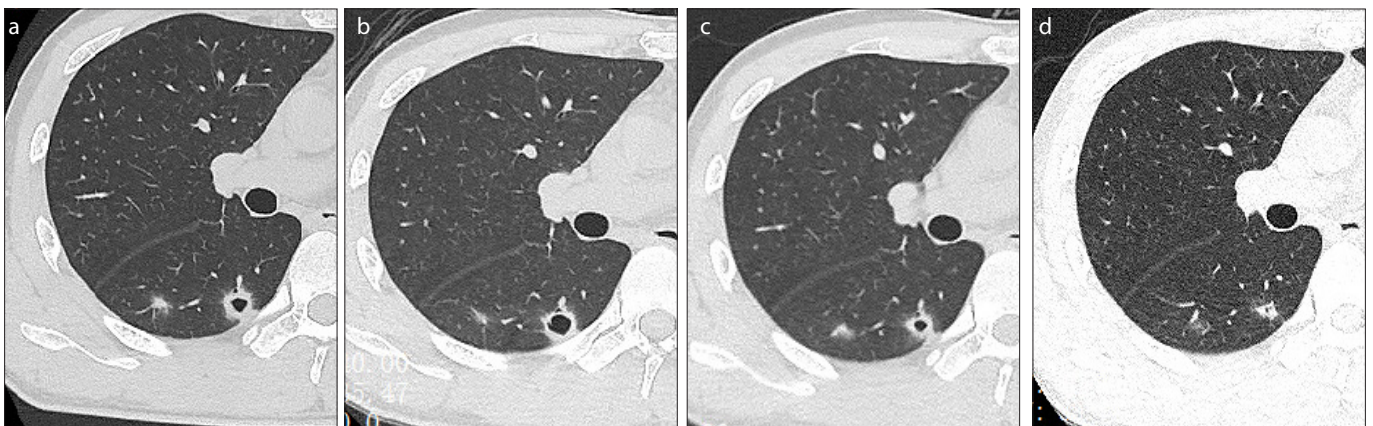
a–d. Imaging changes in a 27-year-old patient with COVID-19 during the course of treatment. Axial lung CT image (a) taken on January 24, 2020 showed some small nodules and a cavitation in the dorsal segment of the right lobe. Axial lung CT image (b) taken on January 28, 2020 showed the lesions were resorbed, but with enlarged cavity. Axial lung CT image (c) taken on February 4, 2020 showed the lesions were more resorbed and cavity was reduced. Axial lung CT image (d) taken on February 19, 2020 showed the cavity disappear.
